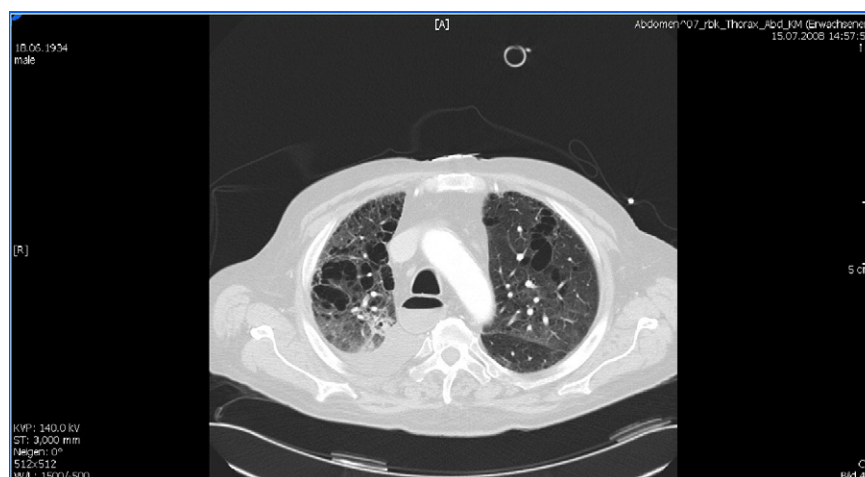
Thoracic CT from patient case 2 with bilateral pulmonary infiltrations and bullous emphysema.
